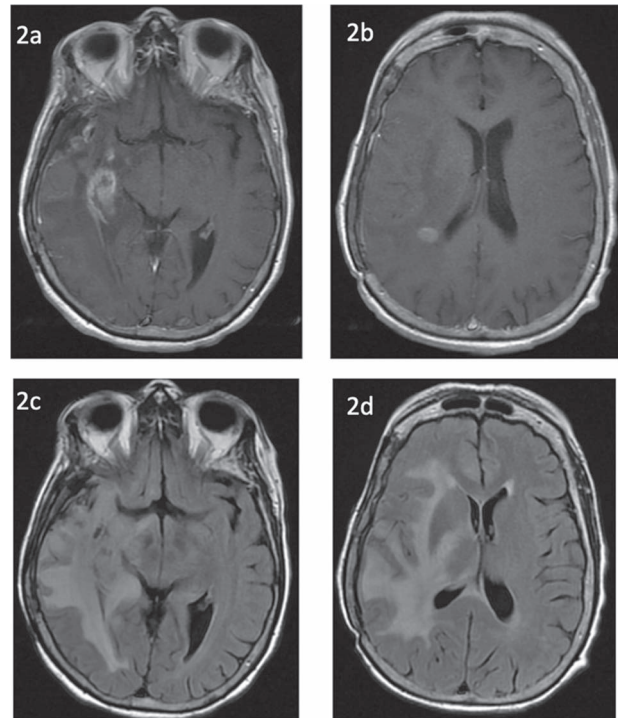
Imaging 8 months post-chemoradiation. (a) Post-contrast T1-weighted MRI reveals increasing enhancement in the right temporal lobe. (b) Post-contrast T1-weighted MRI reveals new enhancement in the right parietal lobe surrounding the lateral ventricle. (c) FLAIR imaging reveals diffuse hyperintensity unresolved since treatment. (d) FLAIR imaging reveals worsening mass effect on the lateral ventricles.
